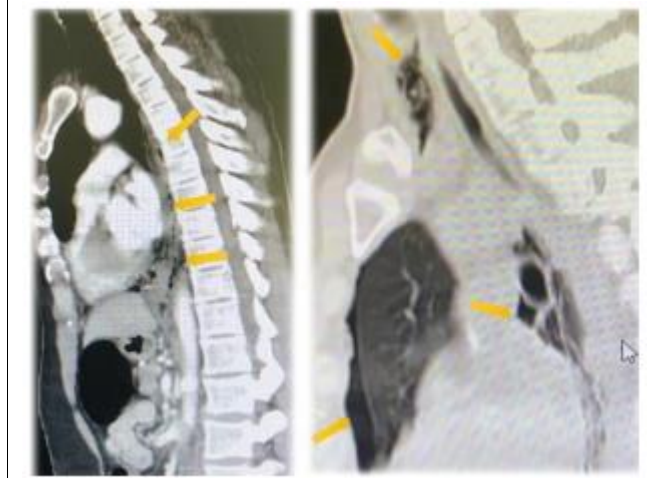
Sagittal scan of CT chest reveals extra-luminal free air in the mediastinum (yellow arrows) and a left-sided pneumothorax.
